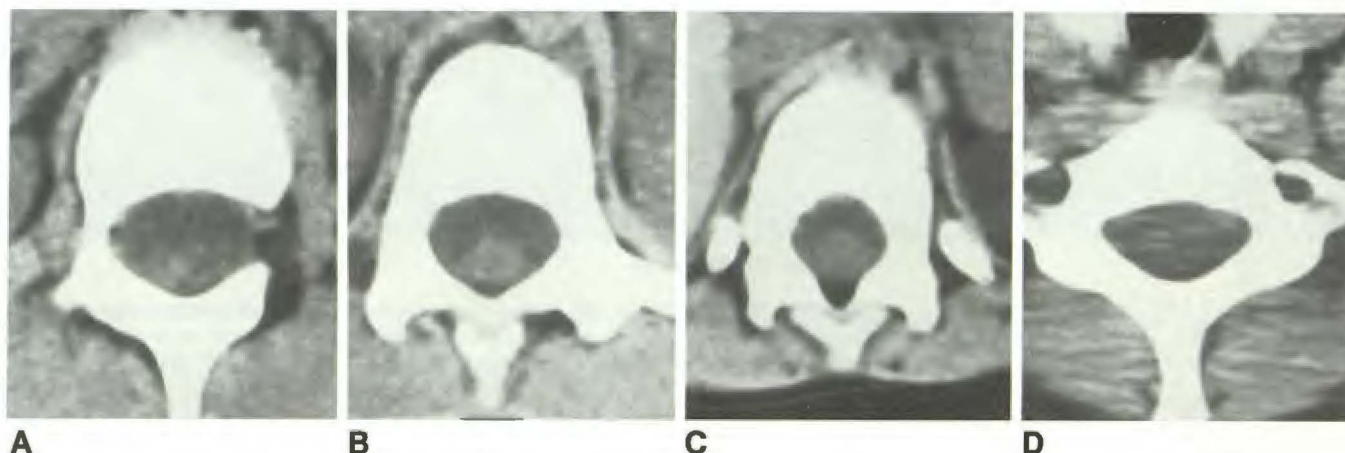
Examples of technical adequacy of noncontrast CT scans.
